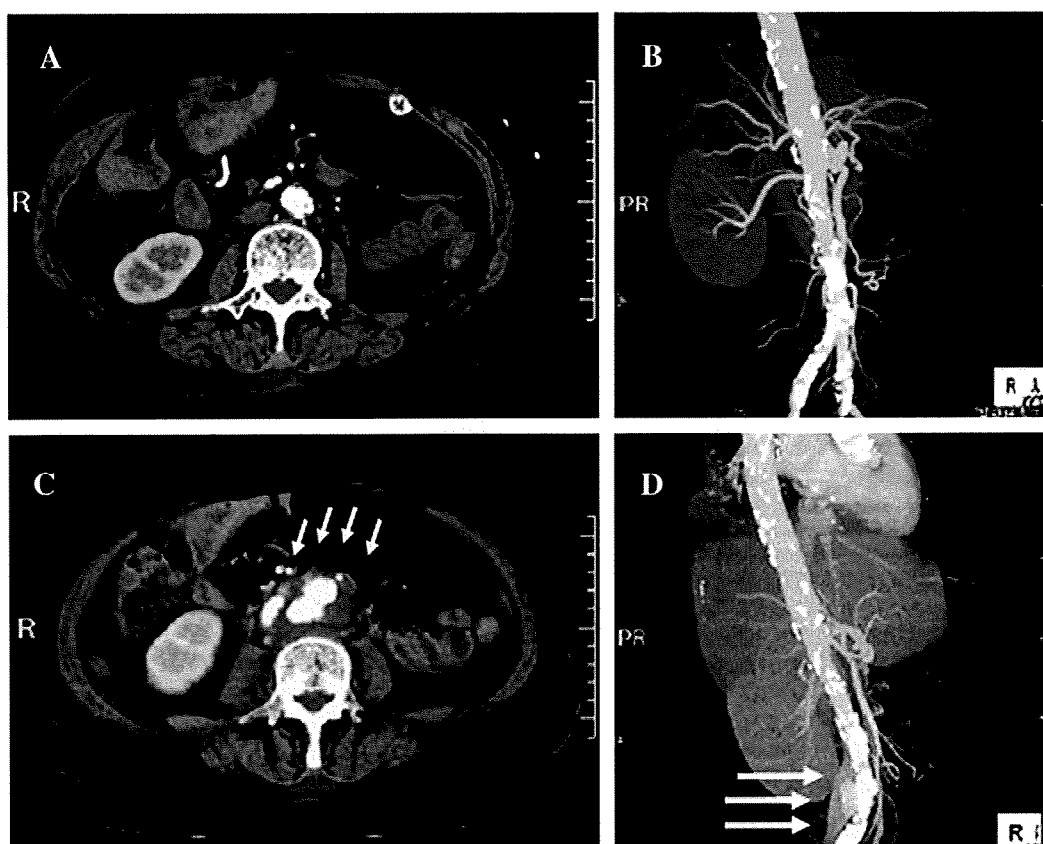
Multi-slice CT changes shown in abdominal aortic pseudoaneurysm. A 64-slice CT revealed no abnormal findings (A, B). On the 31st postoperative day, the 64-slice CT for the second time showed that a 2.1-cm false aneurysm of abdominal aorta proximal to the divergence of common iliac artery (arrows) (C, D).
